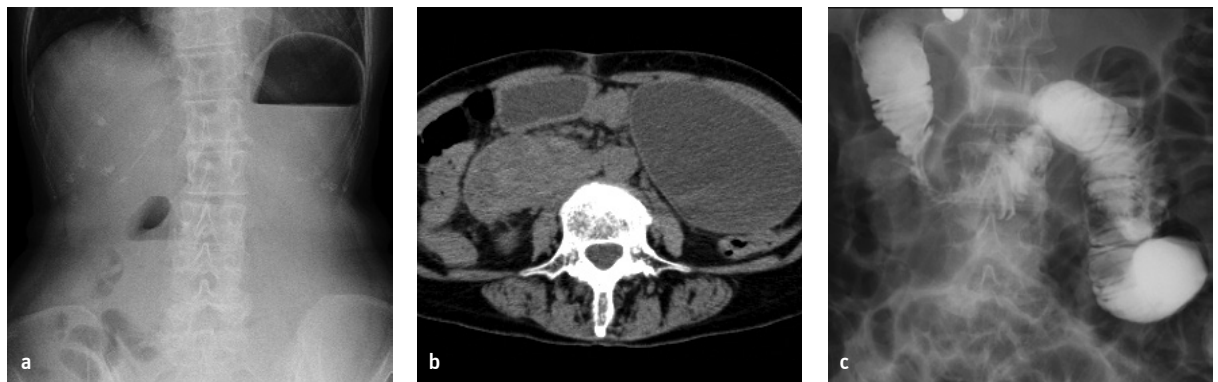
a-c. Abdominal radiographic findings. An upright abdominal X-ray showed small gastric bubble and niveau formation (a), computed tomography showed a hyperdense mass lesion around the pancreatic head (b), an upper gastrointestinal series revealed stenotic change of the duodenum (c)
